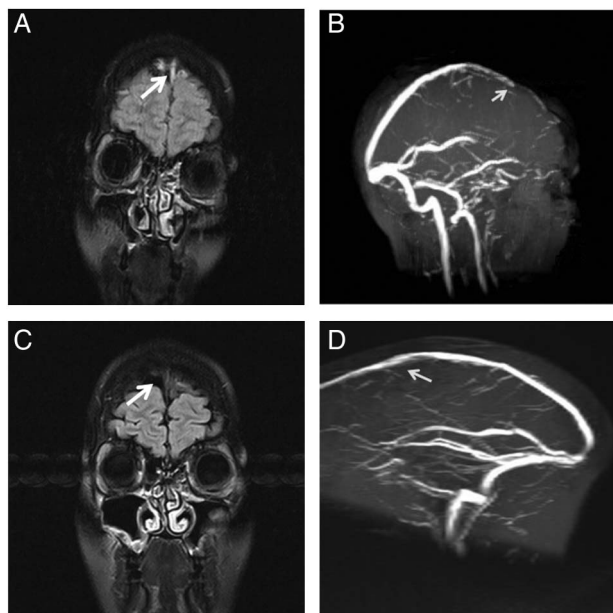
(A) Coronal FLAIR image showing the T2 hyper-intense signal indicative of the clot. (B) Time of Flight venogram (sagittal reformat) showing the filling defect in the anterior half of the superior sagittal sinus. (C) Coronal FLAIR image showing the hypo/isointense signal indicative of flow restoration. (D) Time of Flight venogram (sagittal reformat) showing resolution of the filling defect a year later. FLAIR, fluid-attenuated inversion recovery.
